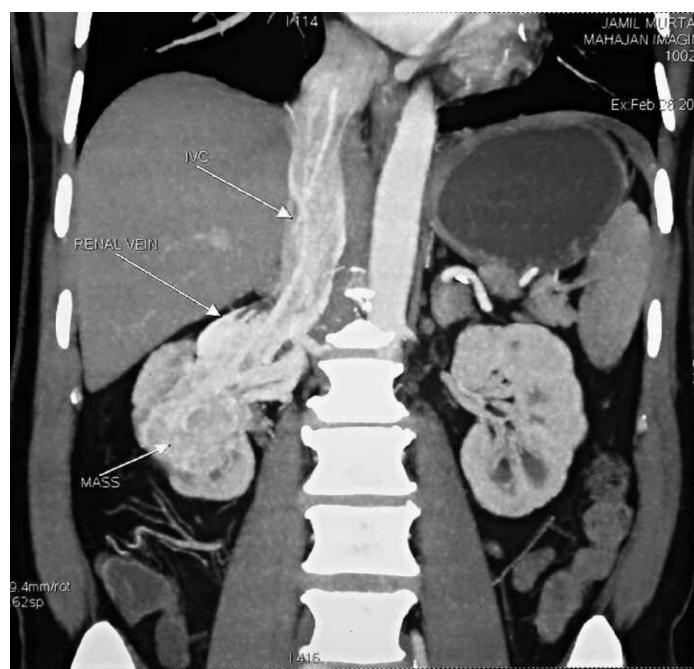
CT (coronal view) showing right renal mass with IVC thrombus extending above diaphragm
